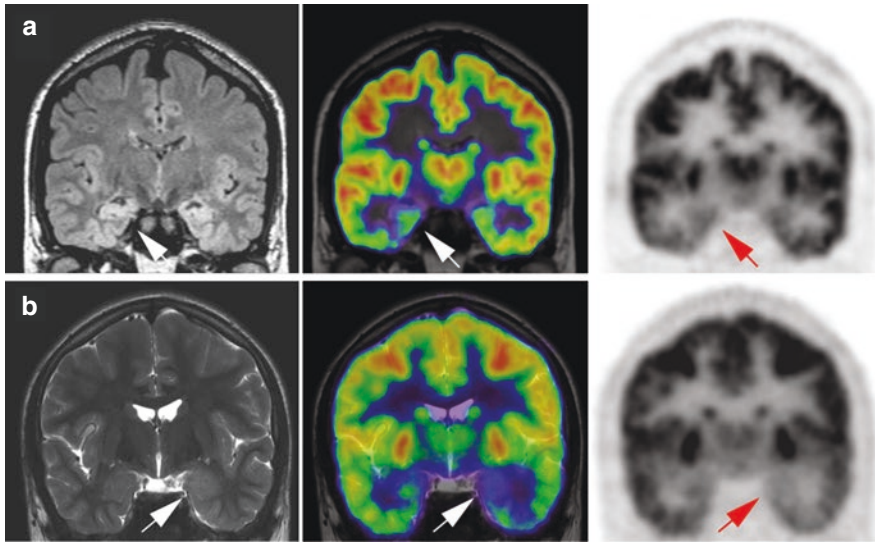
Temporal lobe epilepsy. In patient a (coronal plane of MRI T2-weighted fluid-attenuated inversion recovery (FLAIR), PET/MR fusion, and FDG-PET), MRI showed a discrete atrophy of the right hippocampus (white arrow), without clear hippocampal sclerosis. Fusion PET/MR and PET demonstrated a clear mesio-temporal hypometabolism on the right (white and red arrows, respectively). In patient b (coronal plane of MRI T2-weighted turbo spin echo (TSE), PET/MR fusion, FDG-PET), MRI showed a hippocampal sclerosis at the left (white arrow), with increased T1 and T2 signal, without evidence of atrophy yet. Fusion PET/MR and PET confirmed the results by revealing a left mesio-temporal hypometabolism (white and red arrows, respectively)
